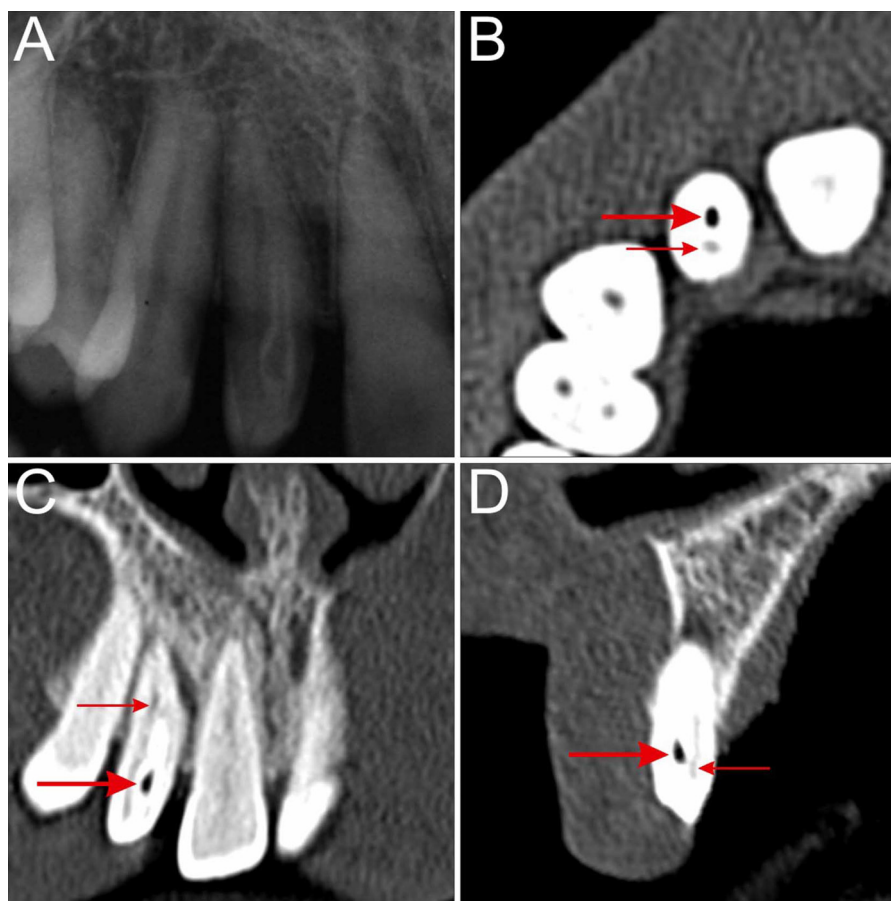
(A) Intraoral periapical radiograph suggestive of Oehlers Type II dens invaginatus. (B) Axial, (C) Coronal and (D) Sagittal spiral computed tomography scan images showing relative positions of the invagination (labially) and main root canal (palatally) [Larger arrow indicating the invagination and the smaller one indicating the main root canal].
